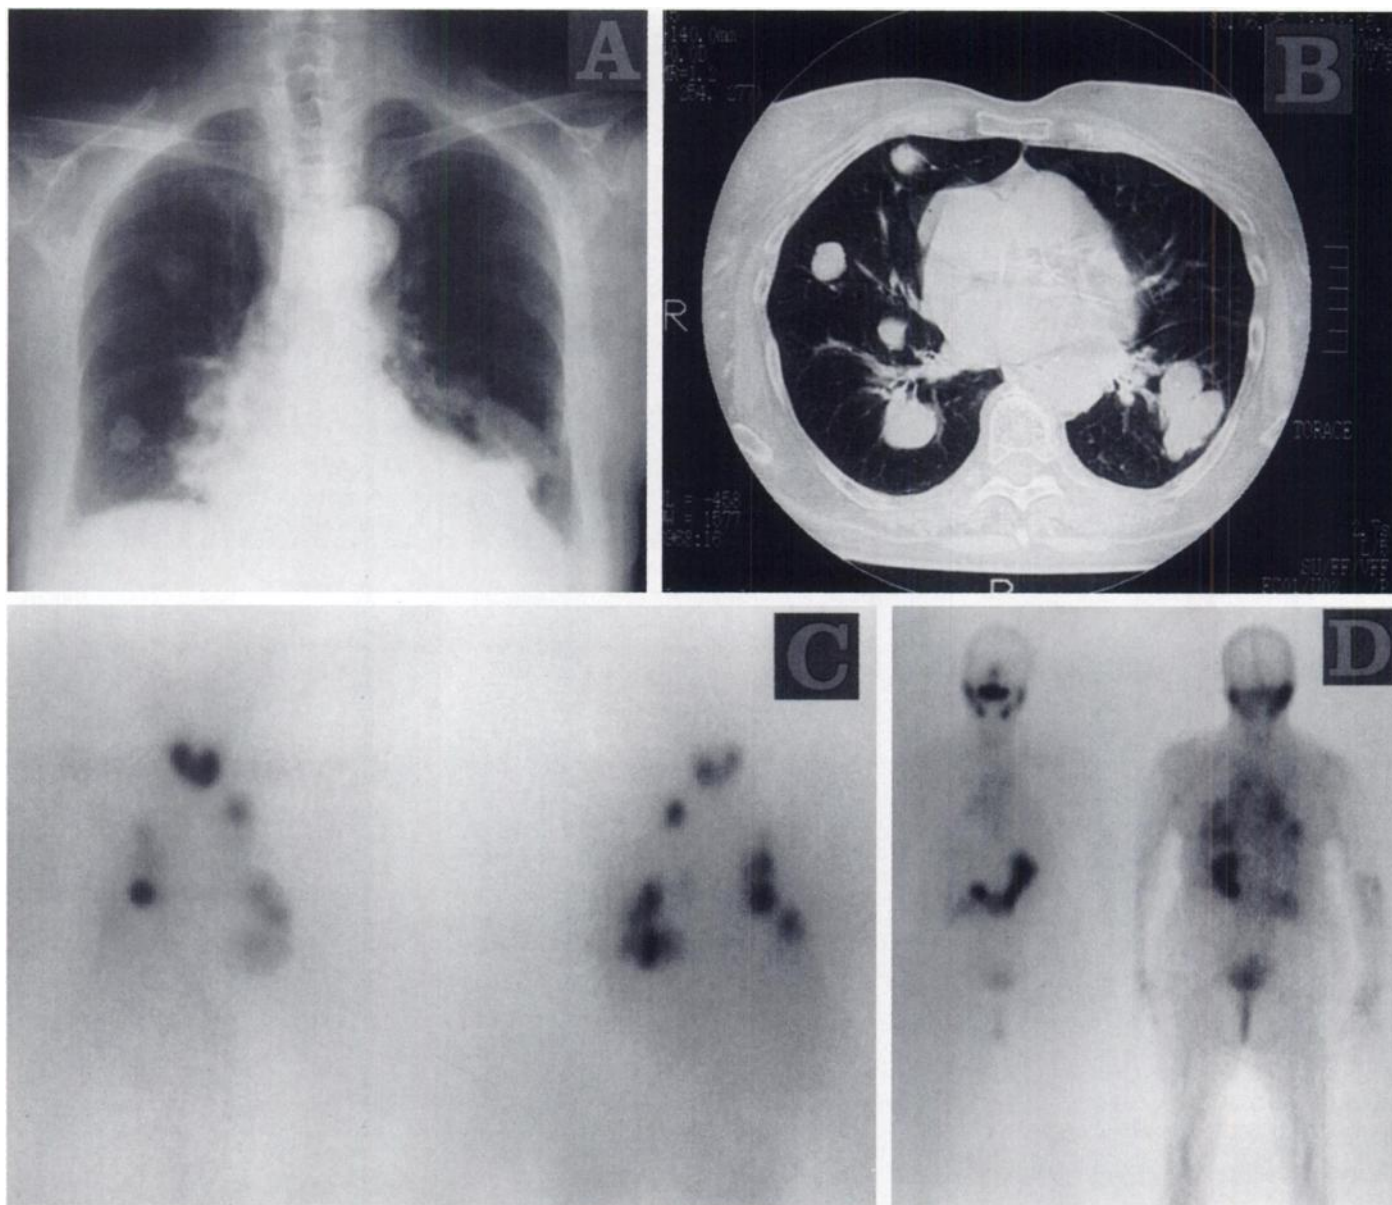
(A) Chest radiograph, (B) chest CT and (D) ^{99m}Tc -pertechnetate whole-body scan performed 6 mo after second radioactive iodine therapy. Note marked reduction in number and size of pulmonary metastases. (C) Iodine-131 whole-body scan demonstrated less-striking reduction in uptake.
